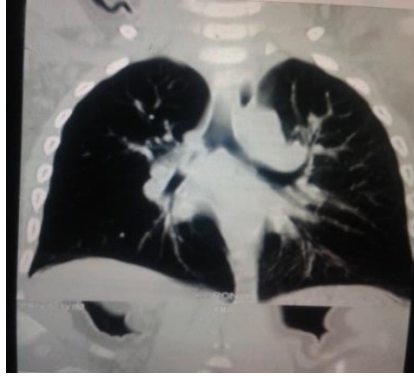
CT Scan showing Foreign Body in right main bronchus
